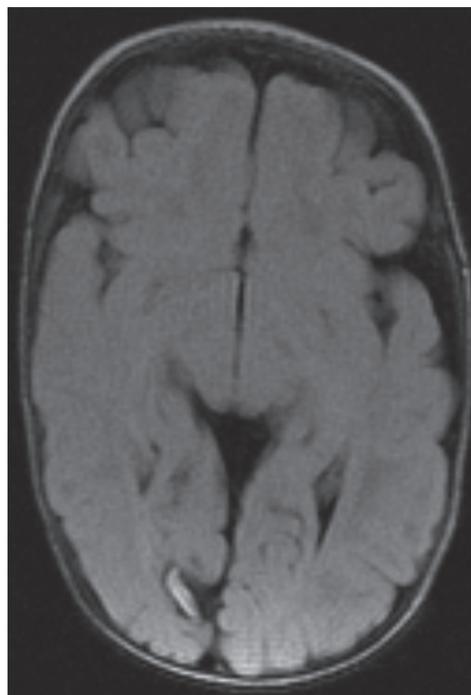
Case 2: MRI of the brain at two months of age showing minimally dilated lateral ventricles with no evidence of hydrocephalus, as well as blood products in the right medial occipital lobe.
